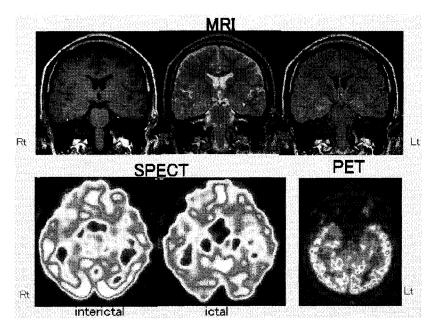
Neuroimaging studies including MRI, interictal and ictal SPECT, and interictal PET detected no abnormality or asymmetry in case 2
